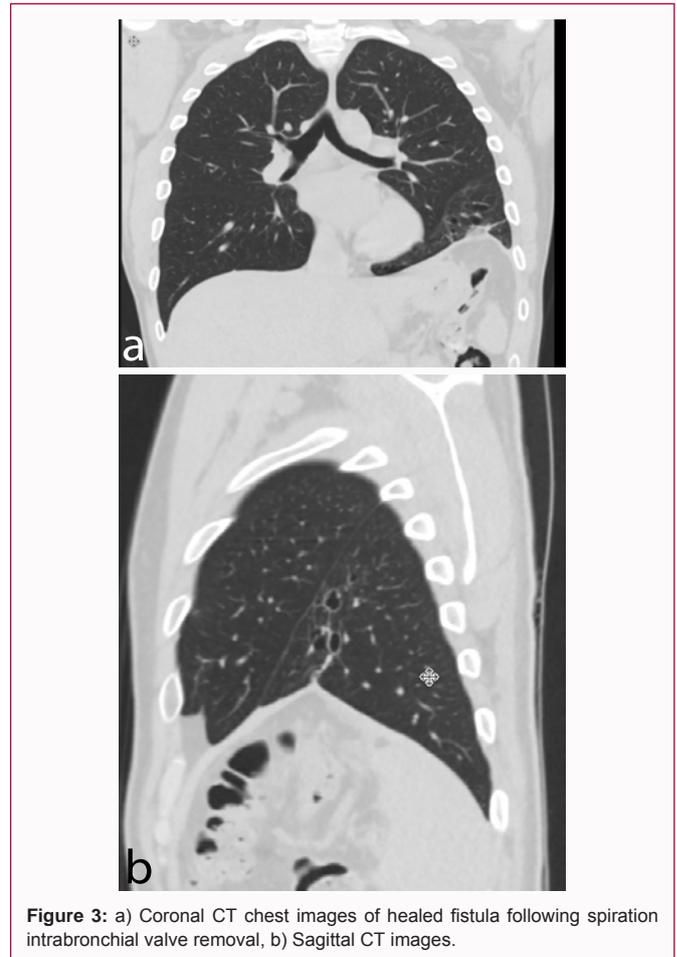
a) Coronal CT chest images of healed fistula following spiration intrabronchial valve removal, b) Sagittal CT images.
